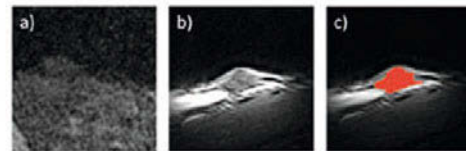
MR images of a site injected with gel obtained at 0.2T for: a) commercial volume coil; b) 20mm surface coil; c) threshold-based segmentation to quantify gel volume.
